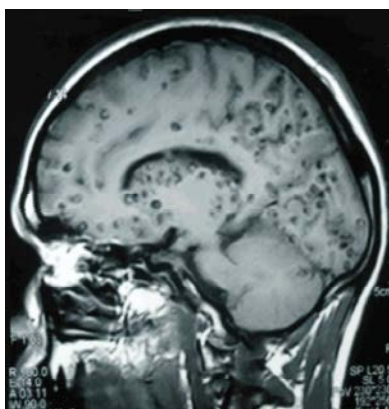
Saggital view MRI showing subarachnoid NCC
